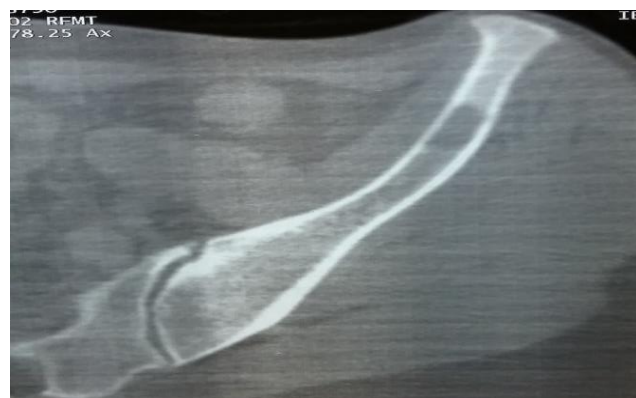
Postoperative CT Scan Showing Iliac Lytic Bone Lesion
